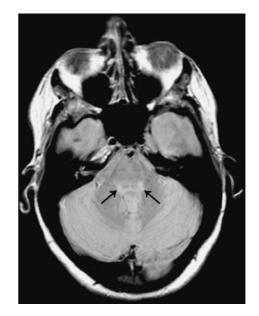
MRI brain scan axial proton density image showing bilateral lesions involving the dorsal pons, particularly the lateral pontine tegmentum (arrows).
